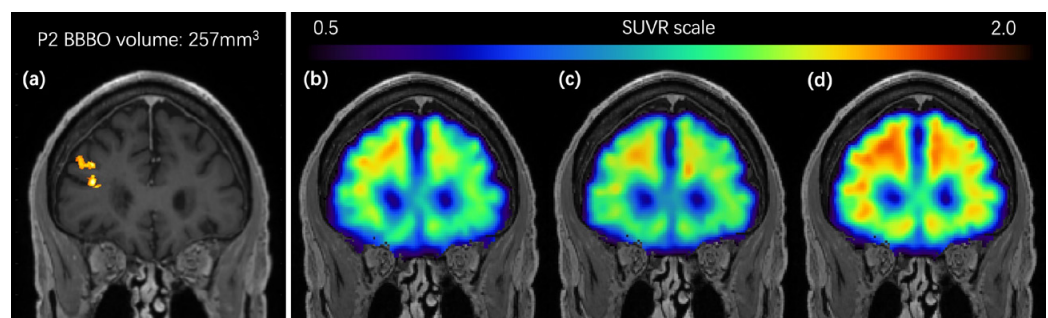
Patient 2 (P2) contrast-enhanced T1 scan (a) indicating BBBO (highlighted) and overlaid with PET SUVR (b) 2 months before treatment, (c) 3 weeks after treatment, and (d) 3 months after treatment.
